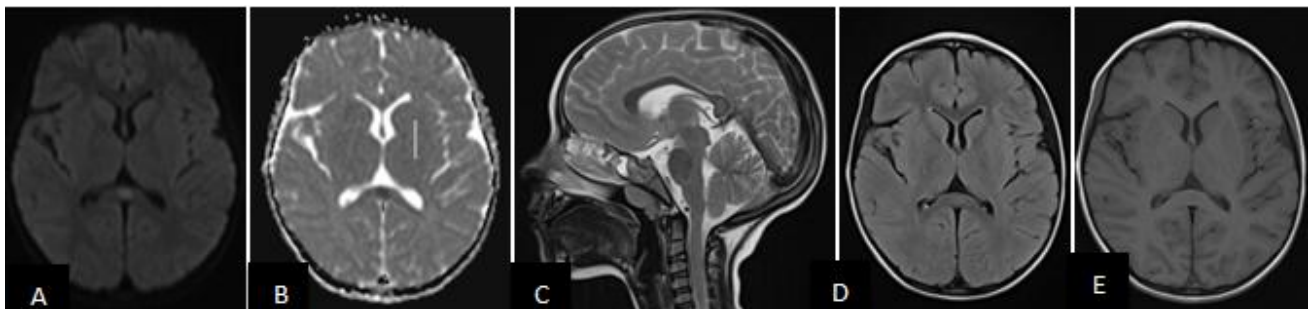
Cerebral MRI without contrast injection at D0 (A: diffusion sequence; B: ADC sequence C:T2, D: FLAIR and E: T1) showing a lesion in the centre of the splenium of the corpus callosum, in hypersignal in diffusion sequence, in hyposignal in ADC, in hypersignal in FLAIR and in isosignal in T 2 weighted sequence and in isosignal in T1 weighted sequence.
